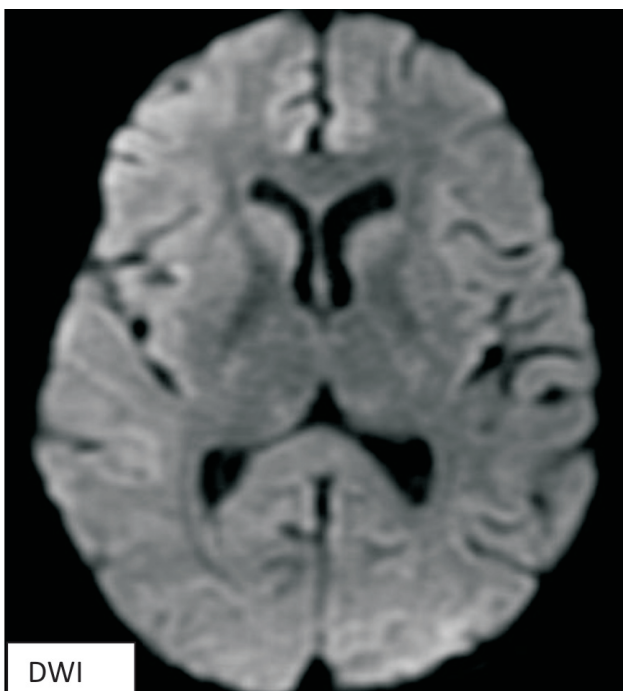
Follow-up MRI done 2 weeks later showed complete resolution of lesion on DWI and T2WI.
